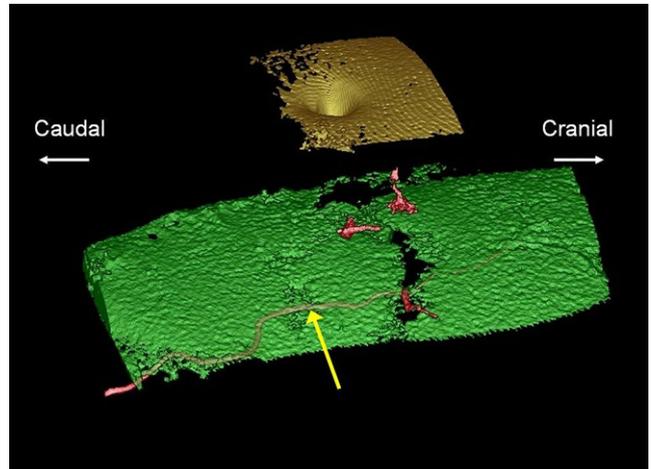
Preoperative CTA and 3D reconstruction using VoNavix software of the dominant perforator in Case 1 (yellow arrow).
